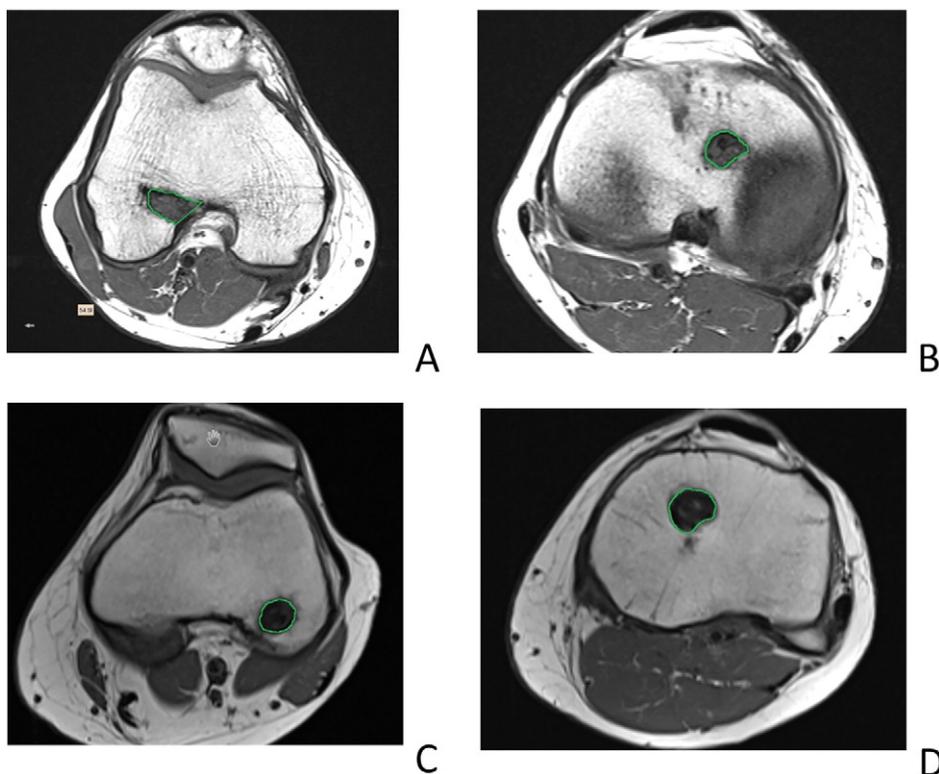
Measurement method of bone tunnel volumes on MRI shown at six months of follow-up of the same patients (Figure 1). The cross sectional area of the femoral and tibial bone tunnel with button (A, B) or screw fixation (C, D) was marked on axial MRI slices.
